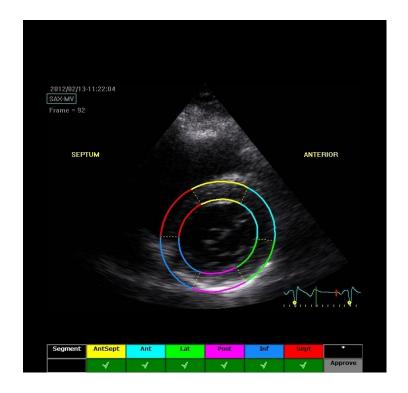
11 Automatic software grading of tracking quality for 2DST in parasternal basal short-axis view
